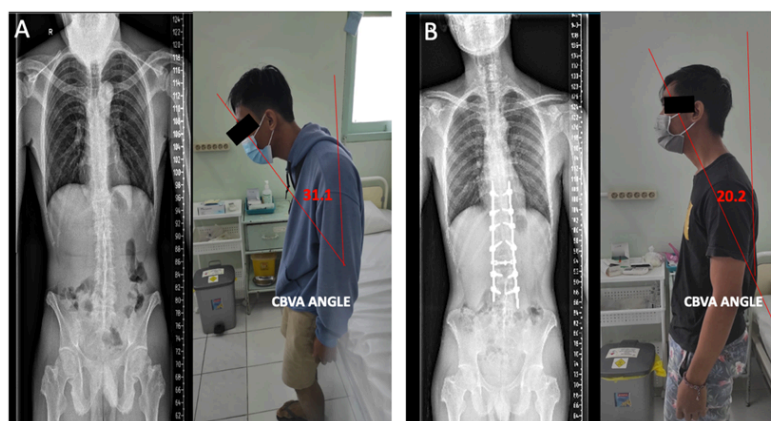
Comparison of preoperative and postoperative conditions: (A) X-ray steaching spine and clinical photo of the patient with preoperative CBVA angle, (B) X-ray steaching spine and clinical photo of the patient with postoperative CBVA angle.
